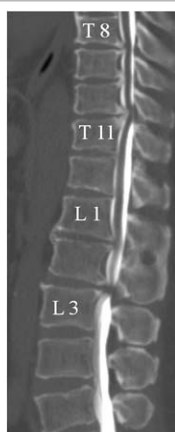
The CT myelography shows areas of OPLL extending from T8 to T11 and L1 to L3.
